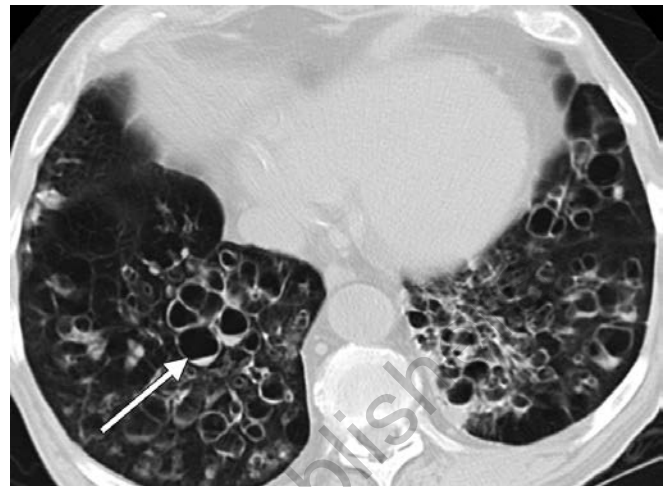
CT chest through the lower lobes showing saccular bronchiectasis. Some of the bronchi have fluid (arrow) in them. This patient developed bronchiectasis from repeated childhood infections
